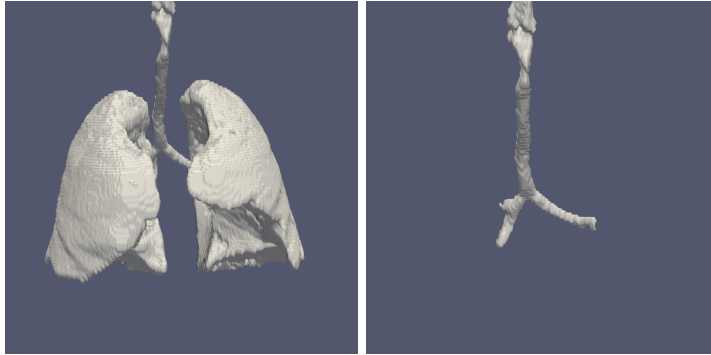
Lungs and trachea segmented from CT data, by thresholding, erosion, dilatation and connected components labeling.
